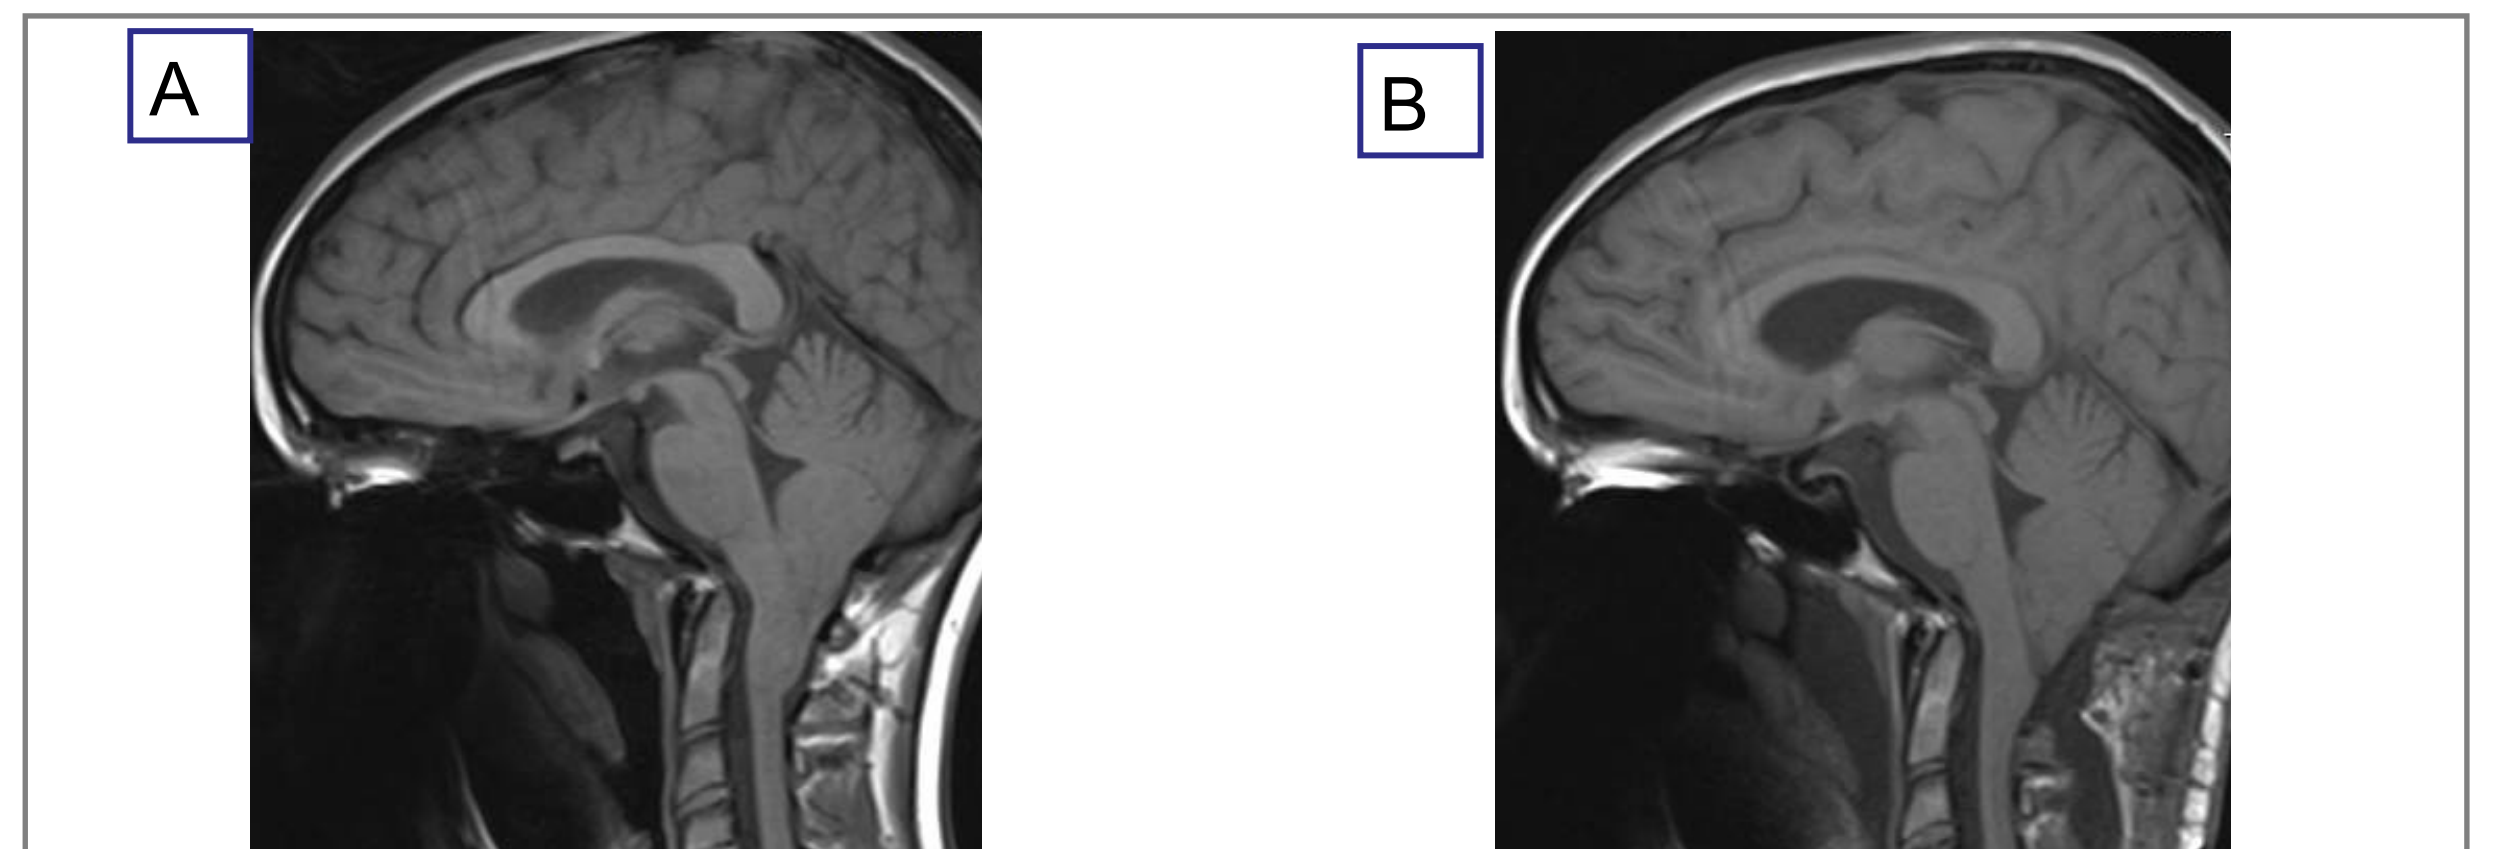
T1 weighted sagittal MRI, pre (panel A) and post (panel B) surgery
